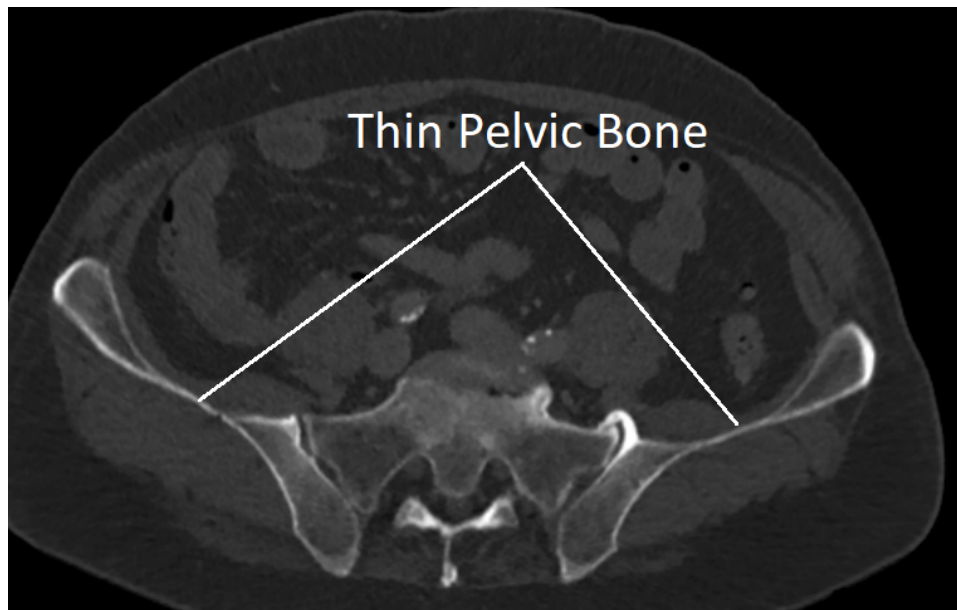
The pelvic bone is extremely thin in places, as can be seen in this CT image. The bone at these locations does not contain any trabecular bone but is entirely cortical bone. Underlying CT data is from the Addenbrooke's Hospital CT Data Collection.
